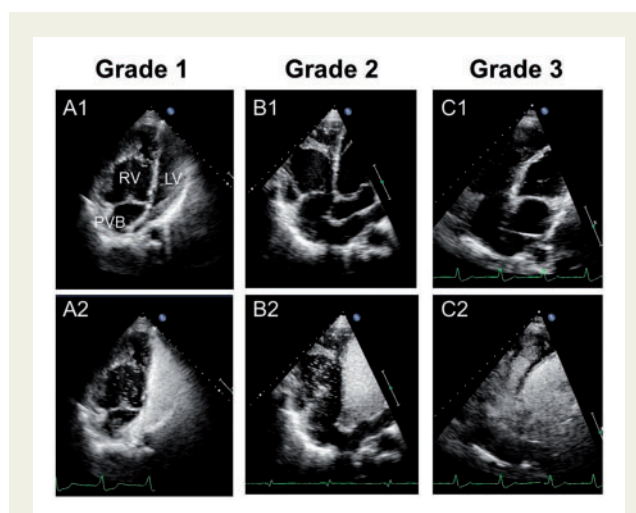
Grading of shunting from systemic venous baffles into pulmonary venous baffles. Upper row, panels A1–C1: still frames of apical four-chamber views prior to bubble-contrast injection. Lower row, panels A2–C2: still frames of apical four-chamber views after bubble-contrast injection. RV, subaortic right ventricle; LV, subpulmonic left ventricle; PVB, pulmonary venous baffle.
